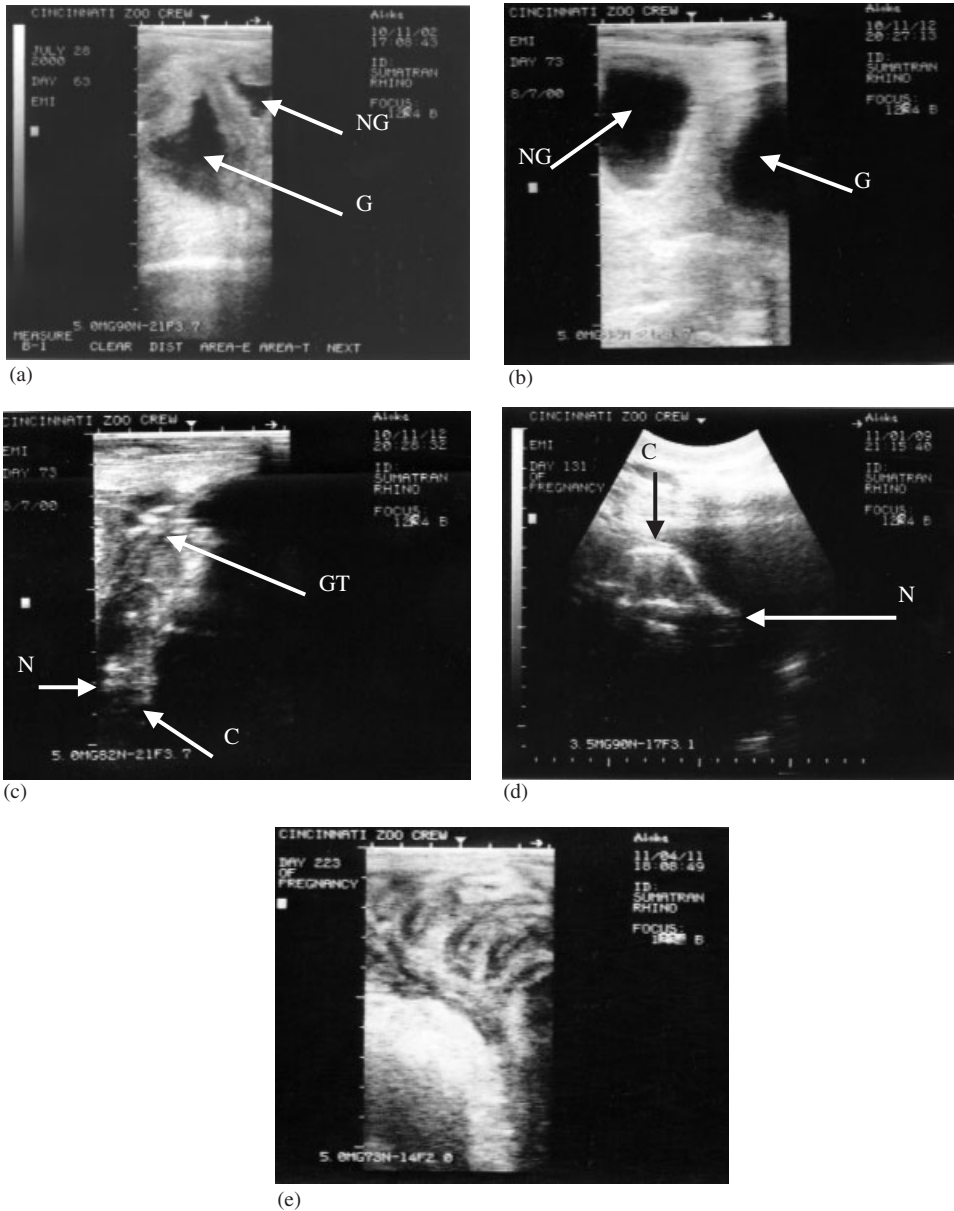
Ultrasound images acquired during pregnancy in a Sumatran rhinoceros. a: Placental invasion of the nongravid (NG) horn was apparent on day 63 of pregnancy. b: By day 73 of pregnancy, both gravid (G) and NG horns were enlarged and filled with allantoic fluid. c: Fetal sex was determined on day 73 based on the location of the genital tubercle (GT) identified in an image of the fetus suspended vertically by the umbilicus with the fetal head ventrally oriented (crown (C) and nose (N)). d: Profile of the fetal head observed during a transabdominal ultrasound examination on day 131 of pregnancy. e: A shift in cervical orientation from horizontal to vertically sloping occurred by mid gestation.
